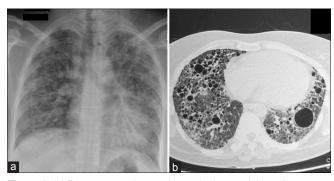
(a) Preoperative chest radiograph showing bilateral extensive reticulonodular opacities obscuring cardiac borders. (b) Preoperative high-resolution computed tomography scan of the chest showing bilateral intra and interlobular septal thickening, patchy areas of consolidation, ground glass opacities, and presence of variable-sized cysts
